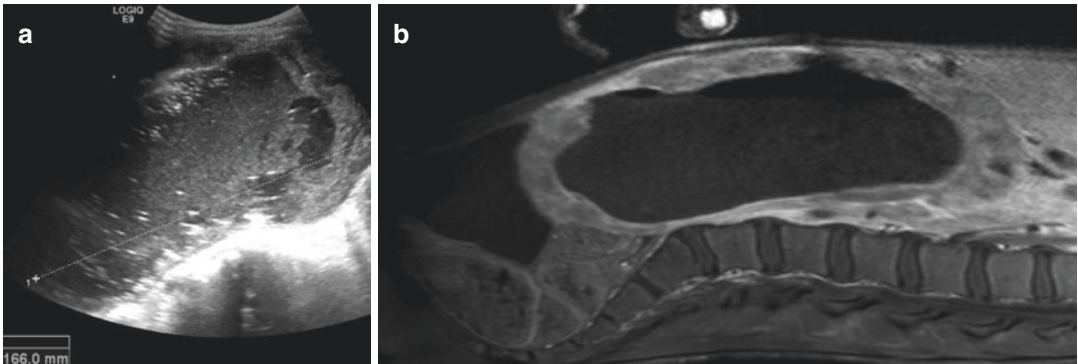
Burkitt Lymphoma—Localized necrotic type in a 14-year-old boy. (a) US: sagittal scan; huge 16 cm abdominal mass with necrotic center. (b) MR imaging post Gd T1-Weighted sequence—Enhancement of the peripheral wall of the necrotic mass
